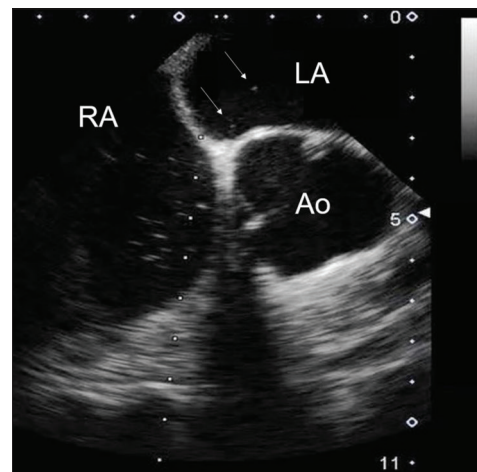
Transesophageal echocardiogram bubble study showing air bubbles (arrow). RA: the right atrium, LA: the left atrium, Ao: the aorta.
